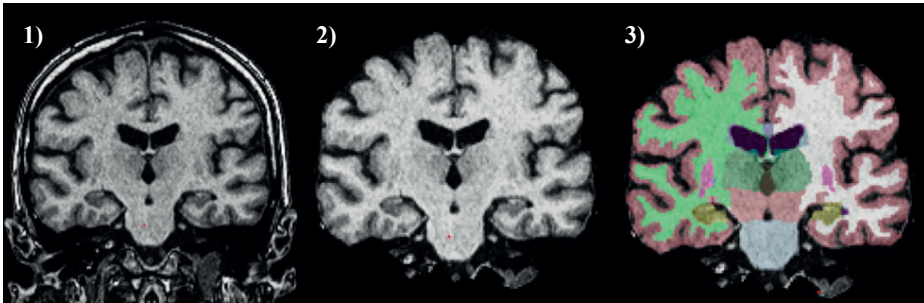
Brain images were assessed with the FreeSurfer software (v. 5.3.0). Coronal T1-weighted brain images; 1) Original image, 2) Removal of the cranium and, 3) Complete segmentation.
